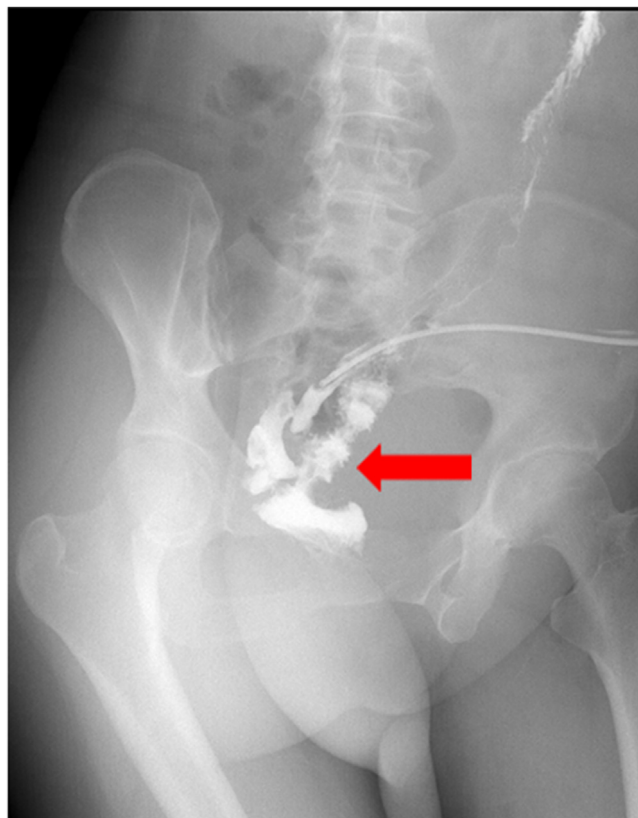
Abdominal plain film with transanal iodine contrast showed that the iodine leaked into the pelvis indicating the existence of a leakage at the anastomosis.
